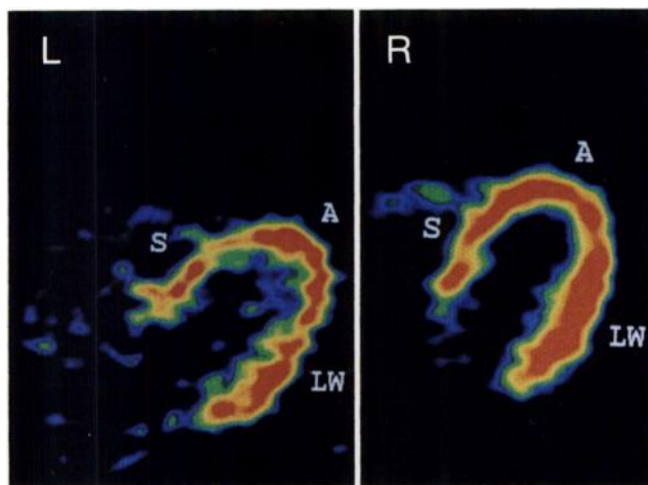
Fluorine-18-FDG PET images of the heart in a diabetic subject (left, heart glucose uptake $48 \mu\text{mole} \cdot \text{min}^{-1}$) and a control subject (right, heart glucose uptake $61 \mu\text{mole}/100 \text{ g} \cdot \text{min}^{-1}$) as determined during insulin clamp. Both images are scaled to the same maximum. S = septum, A = apex, LW = lateral wall of the left ventricle.
